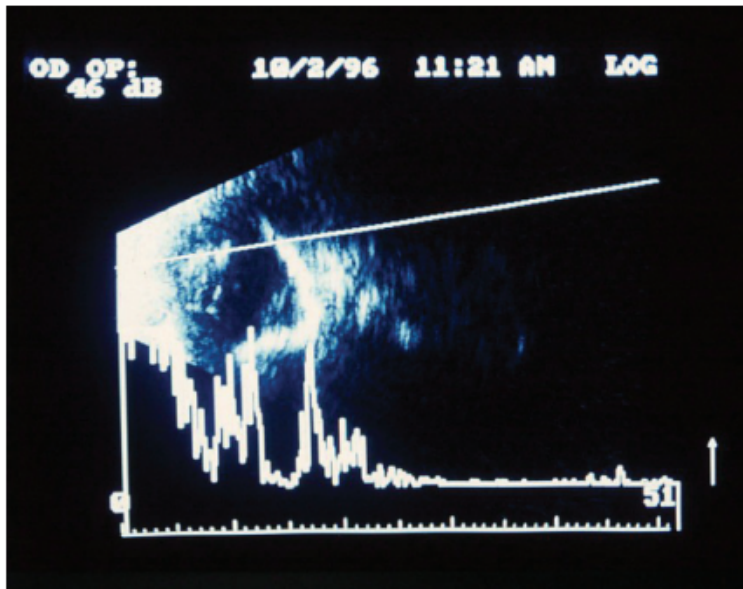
Ultrasonography showing the presence of dense retroretinal echogenicities and retinal elevation
